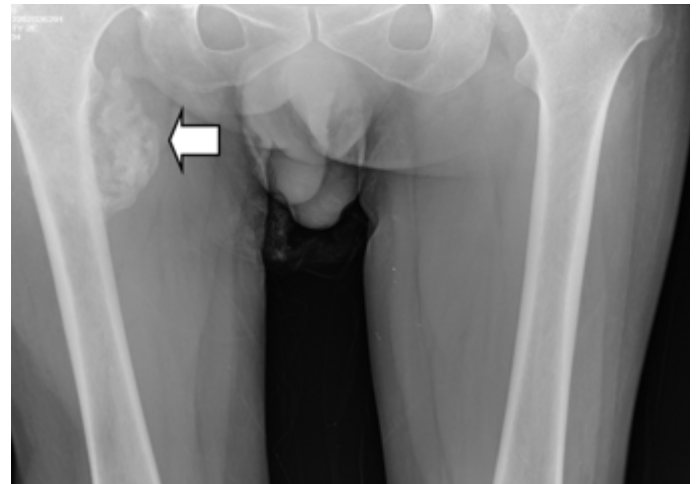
Right femur X-ray which presents abscess lesion on right femur proximal
